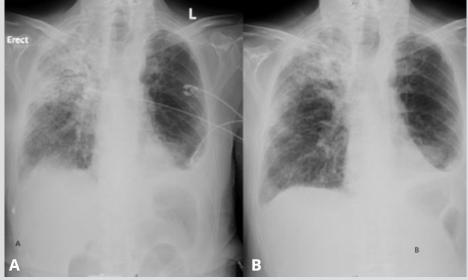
(A) Chest x-ray shows worsening infiltration in the right upper lobe as compared with (B) an x-ray taken only 1 month previously. Transthoracic echocardiography was not suggestive of heart failure
